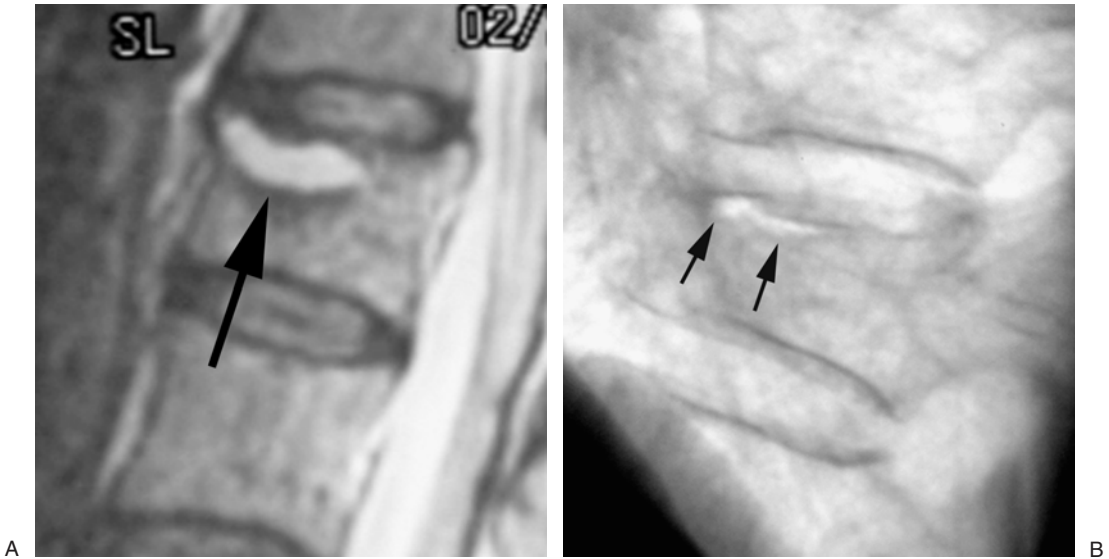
(A) Sagittal MRI (T2 weighted) demonstrates a localized region of high signal below the superior endplate (black arrow) that represents a cavity that was formed by the compression injury. (B) Lateral radiograph that shows a gas-filled cleft (black arrows) below the superior endplate. This finding is equivalent to the MR findings in A.
